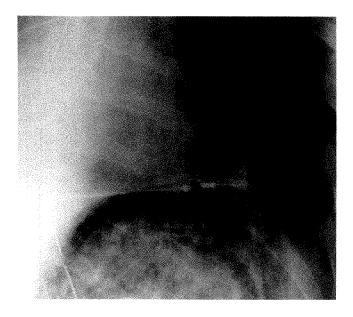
Chest radiograph (coned view of diaphragm) shows extensive gastric emphysema. Remainder of bowel was normal. The patient had nausea and vomiting and diarrhea. Rectal biopsy was negative for cytomegalovirus but positive for graft vs host disease. Pneumatosis resolved after treatment of graft vs host disease.
